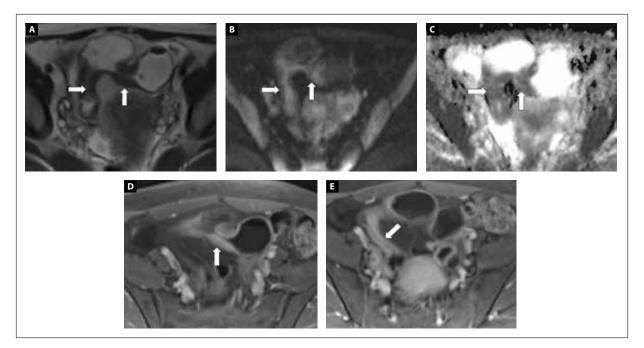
A 27-year-old woman with Crohn's disease underwent 1.5-Tesla magnet magnetic resonance enterography (Avanto, Siemens). Axial half-Fourier acquisition single-shot turbo spin-echo image (A) demonstrates 2 adjacent strictures (white arrows) measuring 2 cm in length with upstream dilation to 3 cm, compatible with stricture. Axial diffusion-weighted image (B) shows high mural signal within the same strictures (white arrows), and the corresponding axial attenuated diffusion coefficient image (C) shows low signal (white arrows), compatible with active inflammation. Axial T1-weighted fat-suppressed Golden-Angle Radial Sparse Parallel image (D, E) shows mural stratification and early enhancement on dynamic postcontrast imaging within the stricture (white arrows), compatible with active inflammation.
